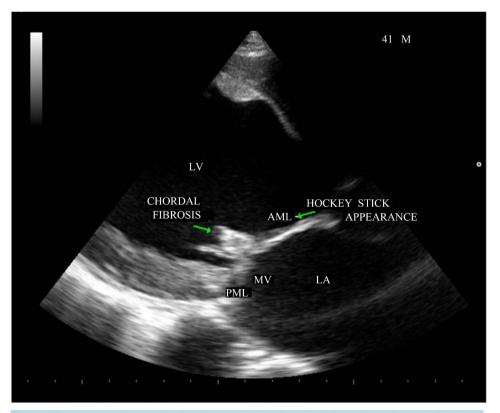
Parasternal long axis view in systole showing the diffuse thickening and fibrosis of chordal apparatus—less amenable to PMC) [24].
